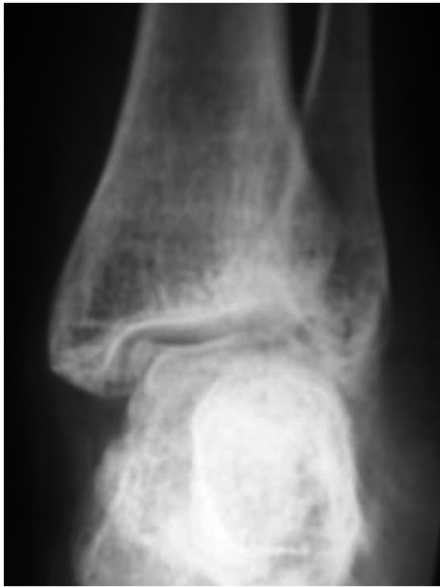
A/P radiograph of patient No.13 a case of polio with ankle instability and osteoporosis
